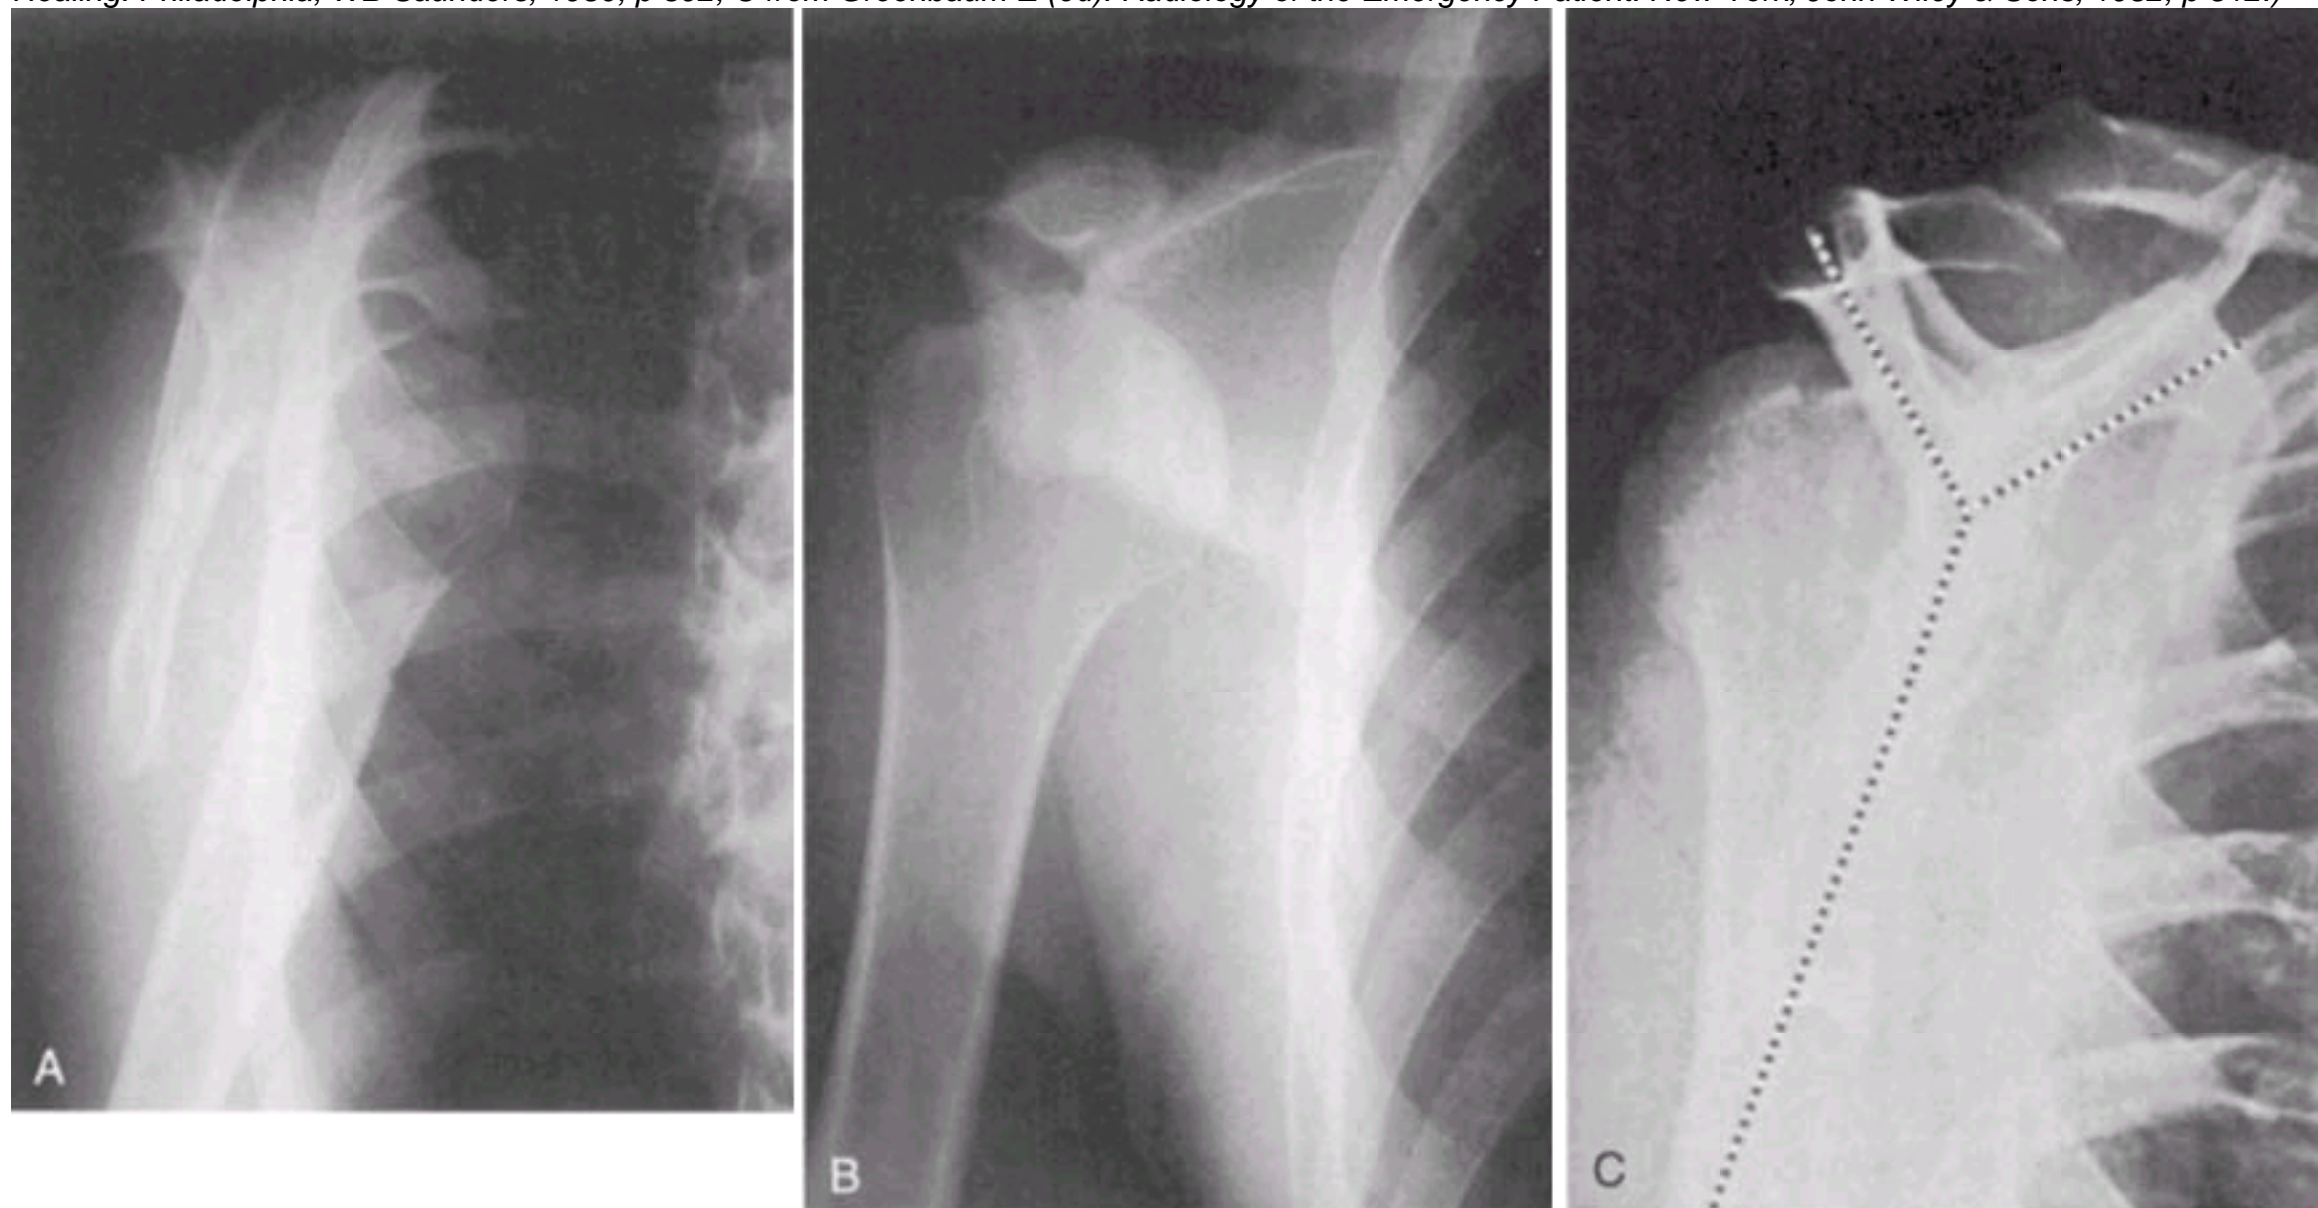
Trauma series includes two views of the shoulder made perpendicular and parallel to the scapular plane. This provides an anteroposterior ( A ) and a scapular Y ( B ) view. The advantage is that roentgenograms may be obtained without moving the patient or removing the arm from the sling. (From Heppenstall RB: *Fracture Treatment and Healing*. Philadelphia, WB Saunders, 1980, p 374. Reproduced by permission.)
